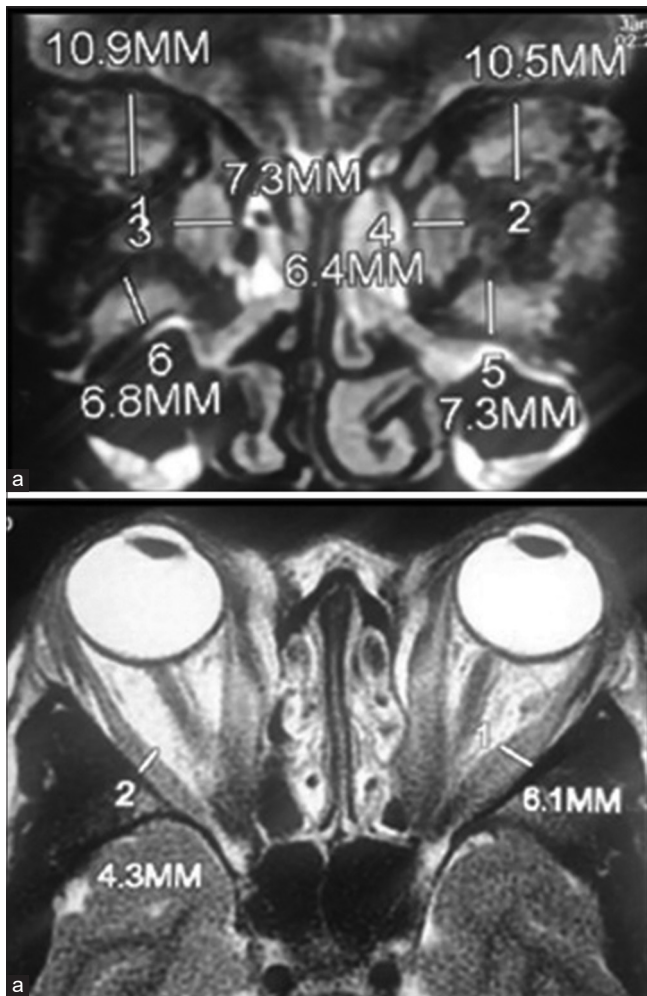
(a and b) MRI T2-weighted images and coronal and axial scans showing gross enlargement of bilateral extra-ocular muscles with a hyper-intense T2 signal and causing apical crowding with optic nerve compression
